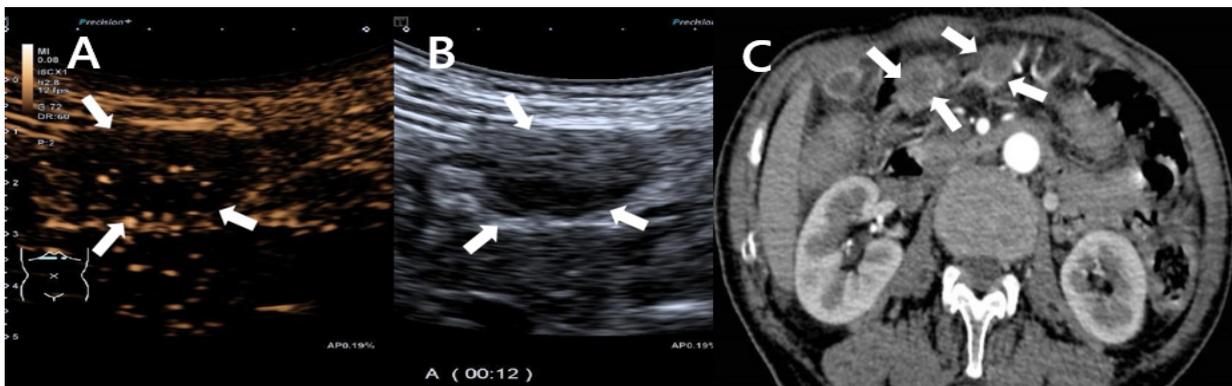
Gastric cancer in a 69-year-old woman. It was confirmed as stage N3 pathologically. (A,B). Grey-scale ultrasound revealed multiple enlarged lymph nodes were seen in the greater omentum (Figure B arrows), CEUS showed with centripetal heterogeneous enhancement in the arterial phase, considering metastatic lymph nodes (Figure A arrows). (C). CECT showed multiple enlarged lymph nodes can be seen in the greater omentum, and circumferential enhancement in the arterial phase (arrows). They were both correctly diagnosed as stage N3.
